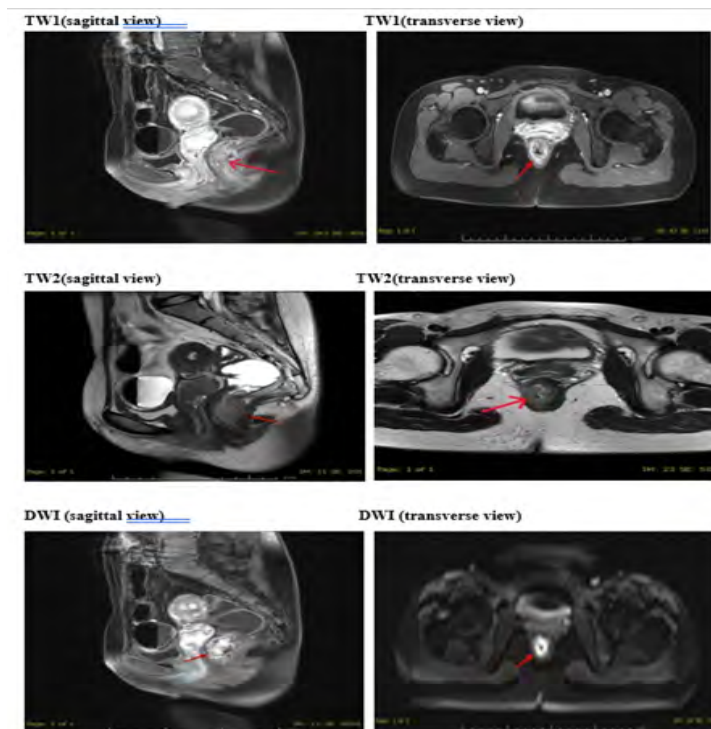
Enhanced magnetic resonance imaging. The lesion is hypointense on T2 and hyperintense on T1. The local uneven enhancement (red arrow) of the intestinal wall at the junction of the lower rectum and the anal canal is about $46 \times 23 \times 20$ mm, and the lower margin is about 14 mm from the anus' edge. It threatens the mesorectal fascia. The tumor is irregular in shape, with uneven signals (T2 and T1) and unclear boundaries; the signal of the muscle layer of the posterior wall of the anal canal is not continuous, where the boundary is slightly blurred with slightly local protrusion. Multiple small lymph nodes are detected in the rectal mesentery and bilateral iliac vascular zone, the largest about 0.6 cm. Diffusion Weighted MRI shows restricted diffusion area of the lesion.
